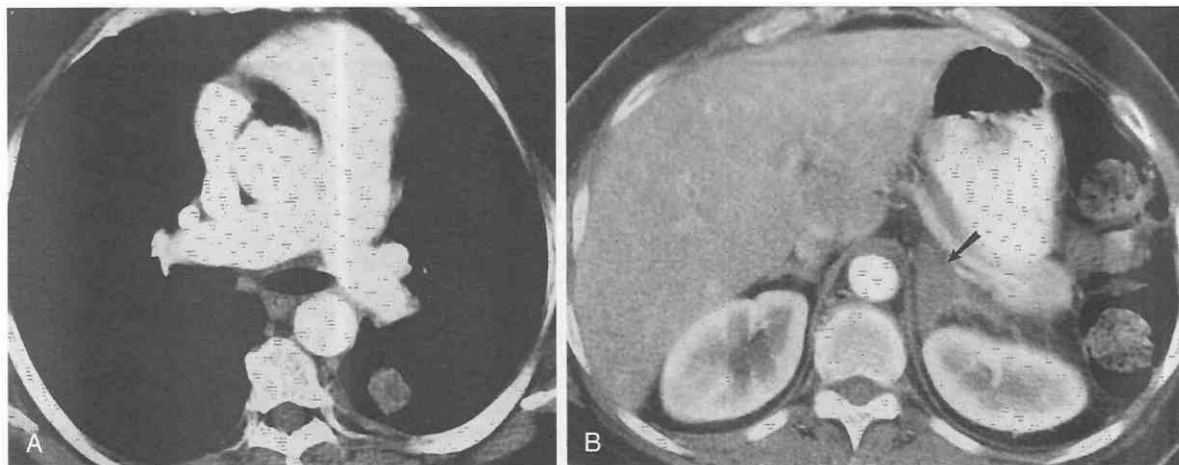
Non-small-cell lung cancer and adrenal metastasis. *A*, CT shows a nodule in the left lower lobe. There is no hilar or mediastinal adenopathy. *B*, CT of the abdomen reveals a left adrenal mass (arrow). Biopsy confirmed metastasis.
